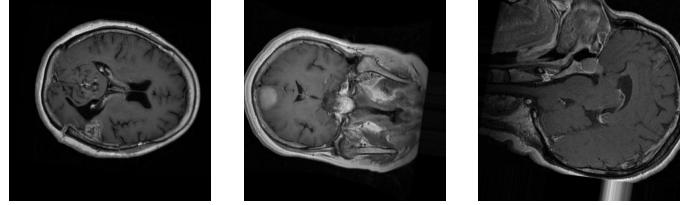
Sample images from MRI scans
